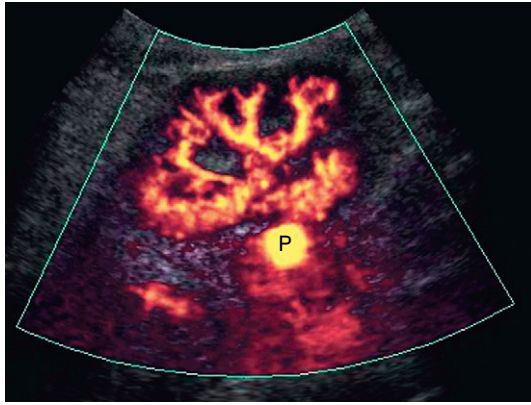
Power Doppler image of a renal transplant 3 weeks after a biopsy. A rounded area of bright flow represents a pseudoaneurysm (P). There is a higher likelihood of this complication with a more centrally directed biopsy, as was the case with this patient.
